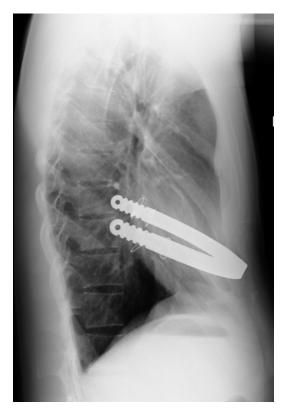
Lateral roentgenogram of patient with recurrent pectus defect less than 1 month after Nuss repair and placement of single bar. Note a longer than recommended length of bar and curvature beyond the mid-axillary line with rotation and displacement
